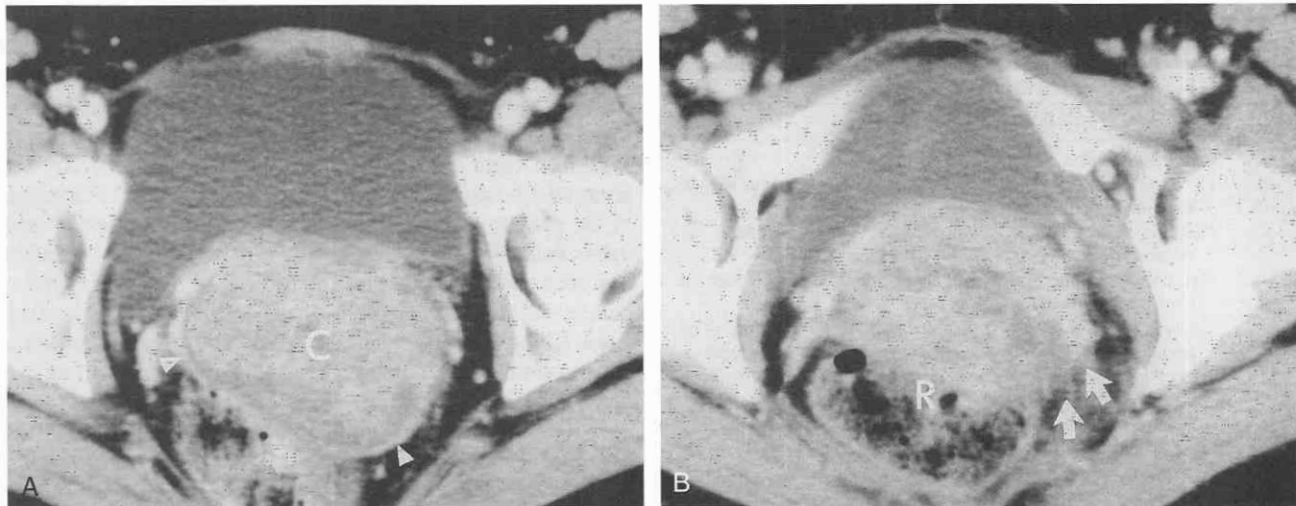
Stage T4 cervical cancer. CT scan through the cervix. A, The cervix (C) is expanded by a heterogeneous enhancing cancer that shows a thin, intact capsule (*arrowheads*). B, At a lower level, invasion of the anterior wall of the rectum (R) and parametrial invasion (*arrows*) are seen.
